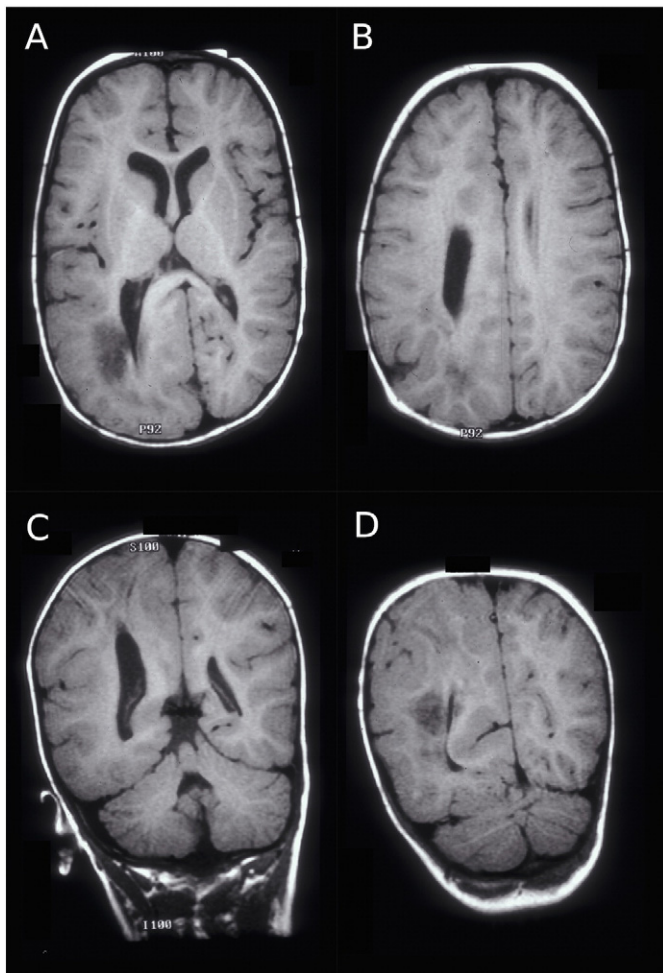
MRI at 18 months of age. Axial (A, B) and coronal (C, D) T1-weighted images demonstrating right hemimegalencephaly. The ventricles are asymmetric and there is thickening of the cortex on the right, particularly in the parietal and occipital lobes.
